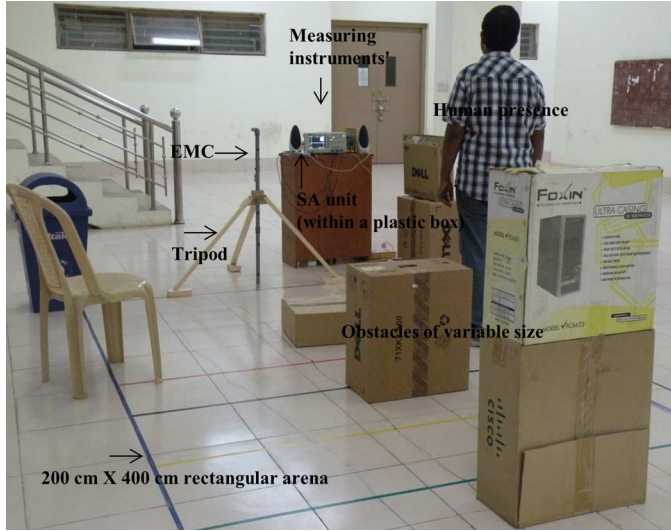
Functional assessment of the electronic mobility cane: Obstacles of variable size were moved in six directions (up, down, right, left, forward, and backward) in front of side and front ultrasonic sensors of the EMC. A rectangular arena of 200 cm \times 400 cm size was prepared for these tests. Safety indicator functions were also assessed during these tests.
